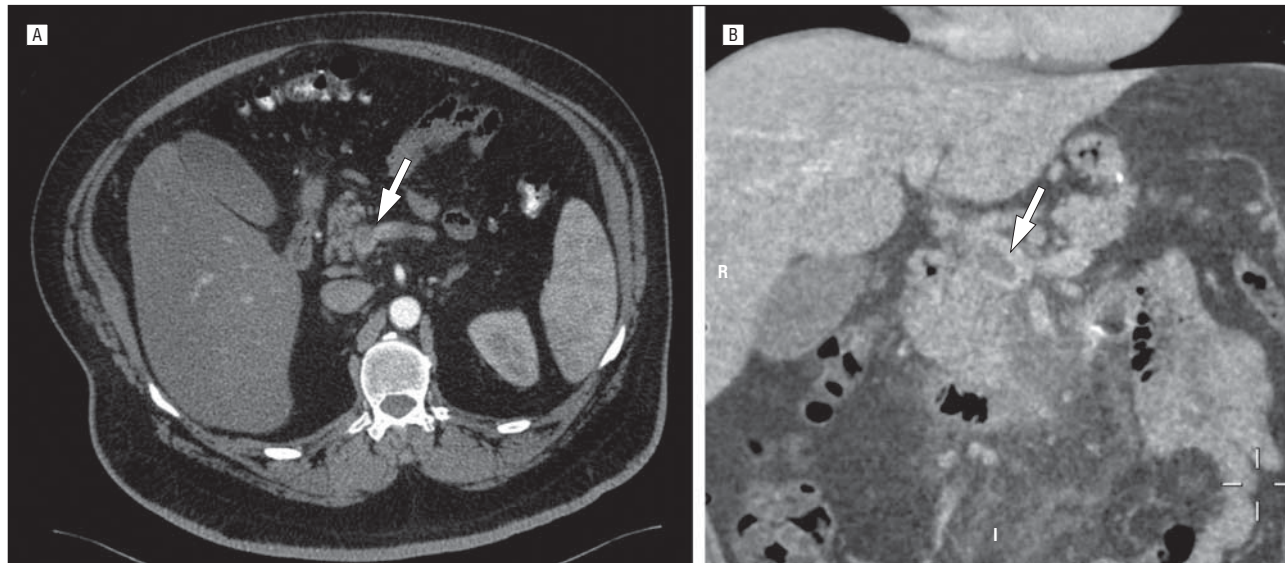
Contrast-enhanced, computed tomographic images (axial image [A] and coronal reconstruction [B]) depicting a thrombus in the portal vein (arrowheads).
